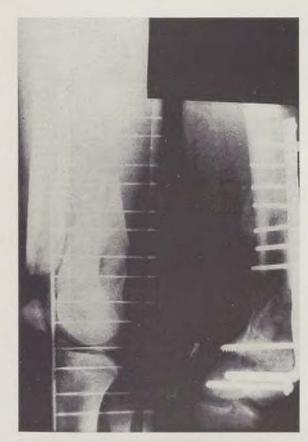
Radiographs before and after the stabilization of the fracture.
